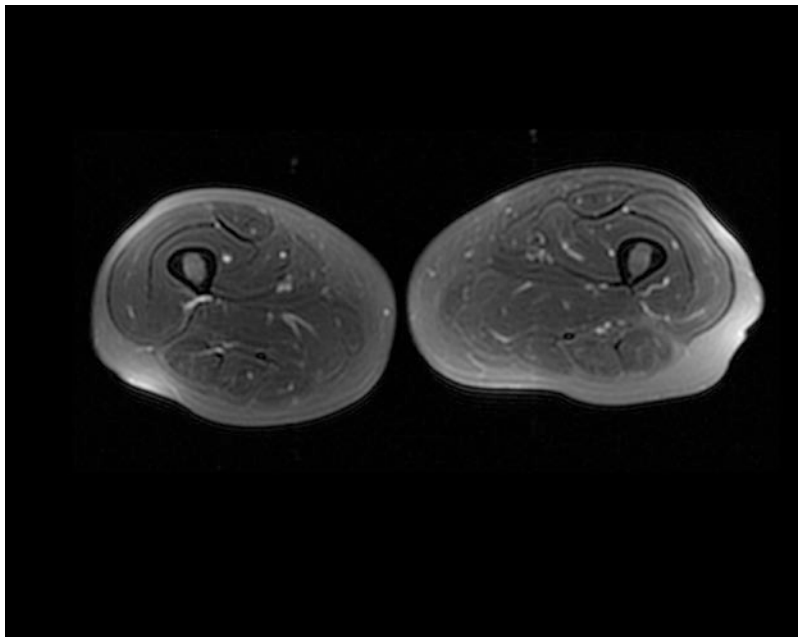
MRI (T2-weighted image with fat suppression) in a patient with glucocorticoid-induced myopathy. A 46-year-old patient was investigated for severe muscle weakness. His history included long-term treatment with medium to high doses of methylprednisolone given for resistant bronchial asthma. Muscle MRI showed mild
